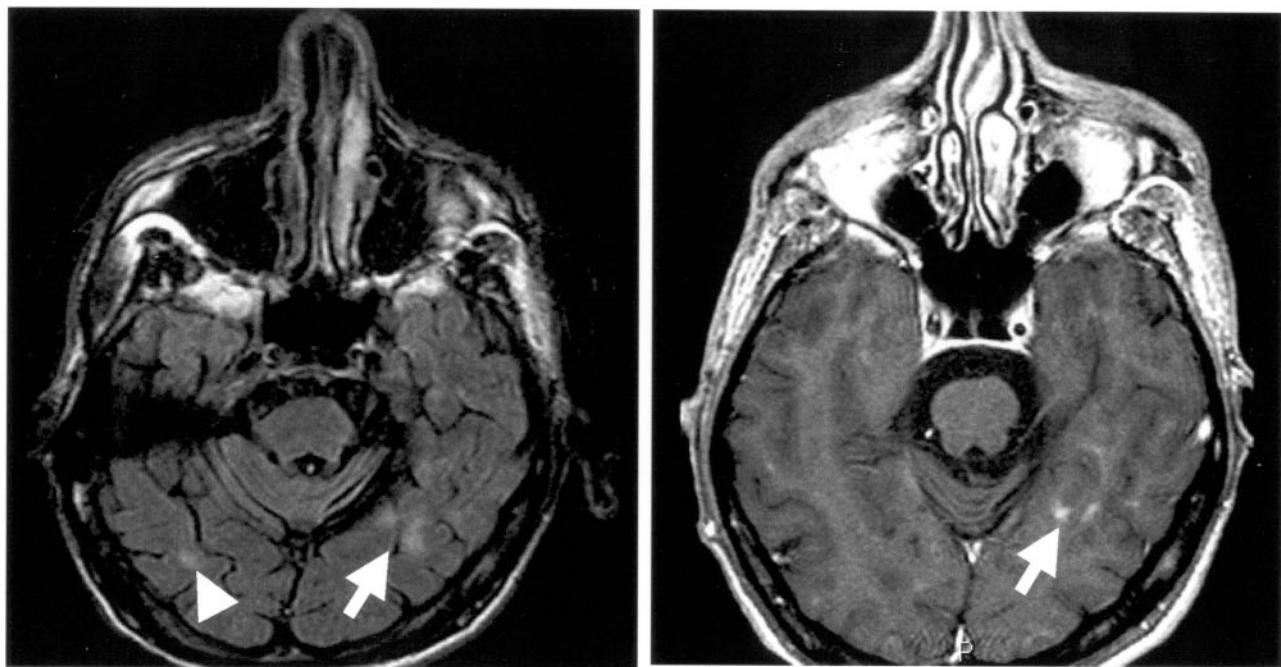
Contrast enhancement of PML lesions. A left temporal lobe lesion seen in FLAIR (arrow, left panel) enhances after gadolinium injection in T1-weighted image (arrow, right panel), whereas a right temporal lobe lesion is only detected in FLAIR sequence (arrowhead, left panel).
